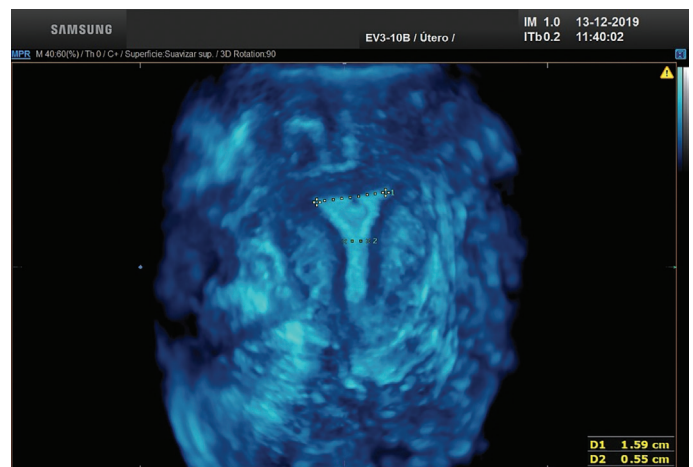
3D coronal ultrasound view of a hypoplastic uterus, demonstrating a reduced interstitial distance of 1.59 cm.
